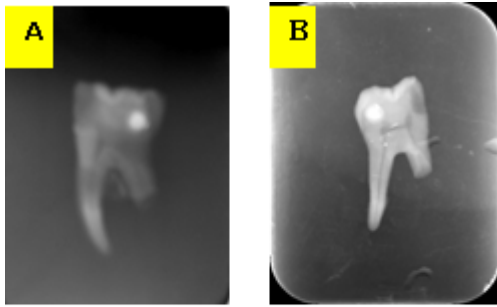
Showing one of our studied sample molar which was irradiated with different imaging systems, a) conventional periapical radiography, b) digital periapical radiography.
